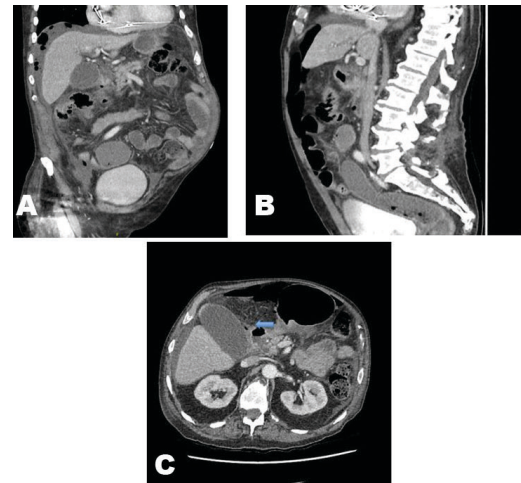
(A) Coronal view of CT intraperitoneal free fluid and pneumoperitoneum. (B) Sagittal view of focal discontinuity in the posterior wall of the pyloric region. (C) Arrow indicating possible site of perforation in the gallbladder wall.
